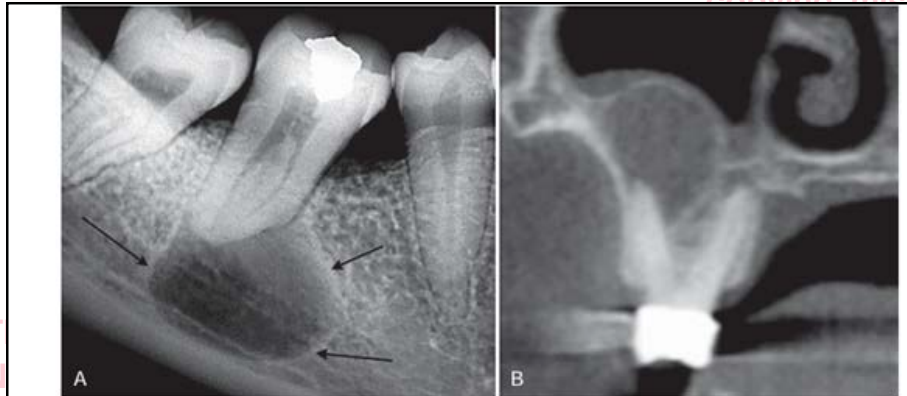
A, A periapical film of a radicular cyst reveals a lesion with a well-defined cortical boundary (arrows). Note that the presence of the inferior cortex of the mandible has influenced the circular shape of the cyst. B, A coronal cone beam CT image of a radicular cyst related to the buccal root of a maxillary molar. Note the circular shape of the cyst as it invaginates the maxillary sinus. (Courtesy
